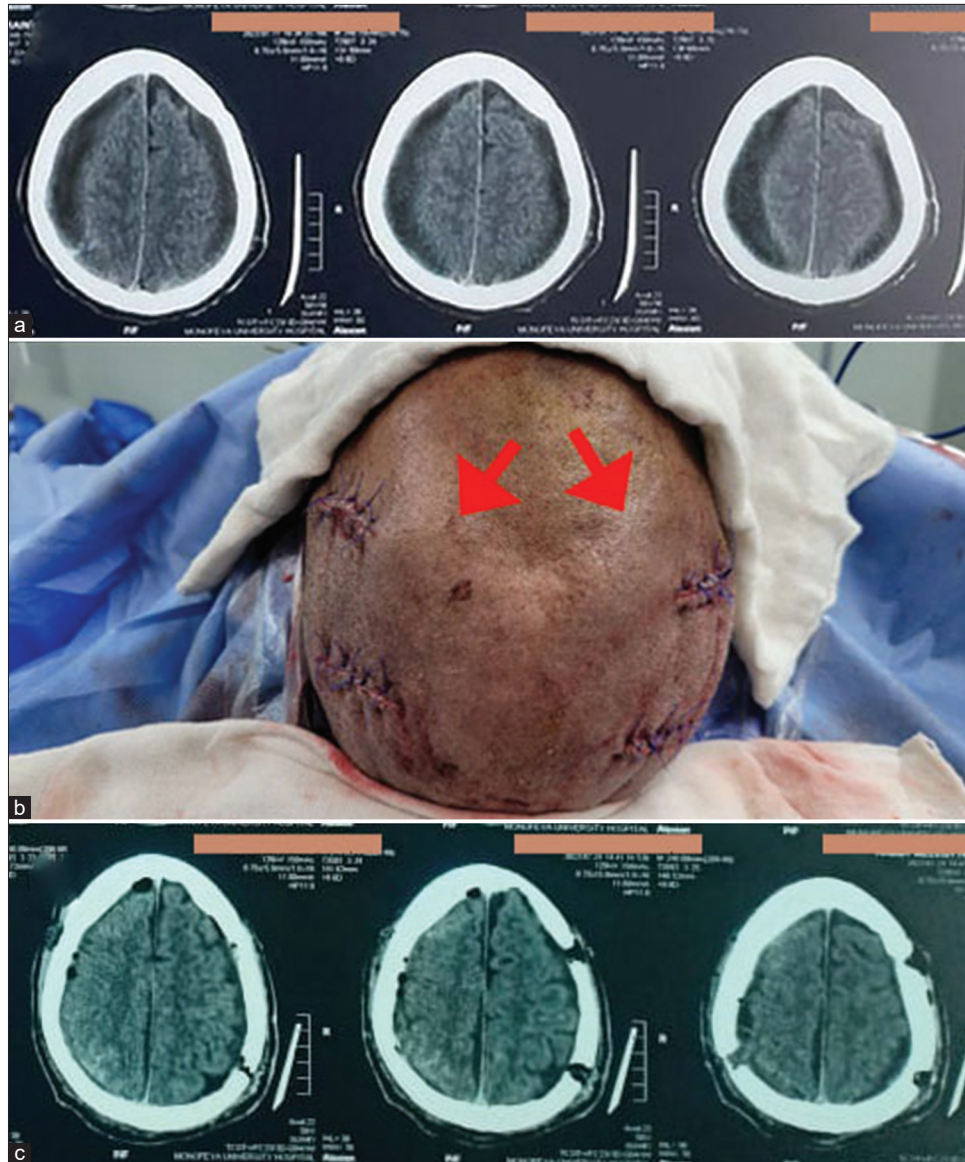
A male patient 68 years old presented with confusion, dysarthria, and quadriparesis. Glasgow coma scale = 13. (a) Preoperative computed tomography (CT) brain revealed bilateral chronic subdural hematomas with bilateral brain compression. (b) Surgical evacuation was done bilaterally at the same time with two burr holes on each side. Subgaleal pockets (red arrows) were created by blunt subgaleal dissection, which was done bilaterally, and closure was done without drain. (c) Postoperative CT brain revealed good decompression.
